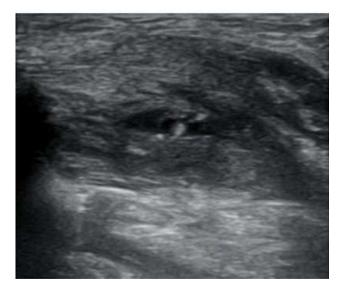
Ultrasound of the right wrist showed a 5×3mm, well-defined, thin-walled, cystic lesion with an eccentric, echogenic focus measuring around 1.5 mm in diameter in the subcutaneous plane. The hypoechoic area surrounding this cyst showed significant exudative fluid collection within. The adjacent soft tissues were thickened and irregular, suggestive of edema.
